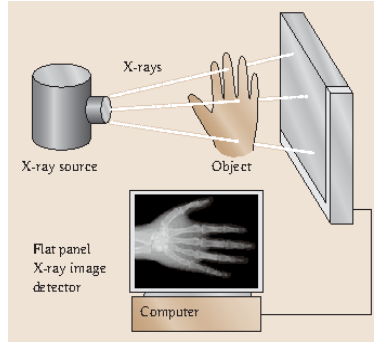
Acquisition of an X-ray image, with an X-ray source, object and an X-ray imaging detector [1].
